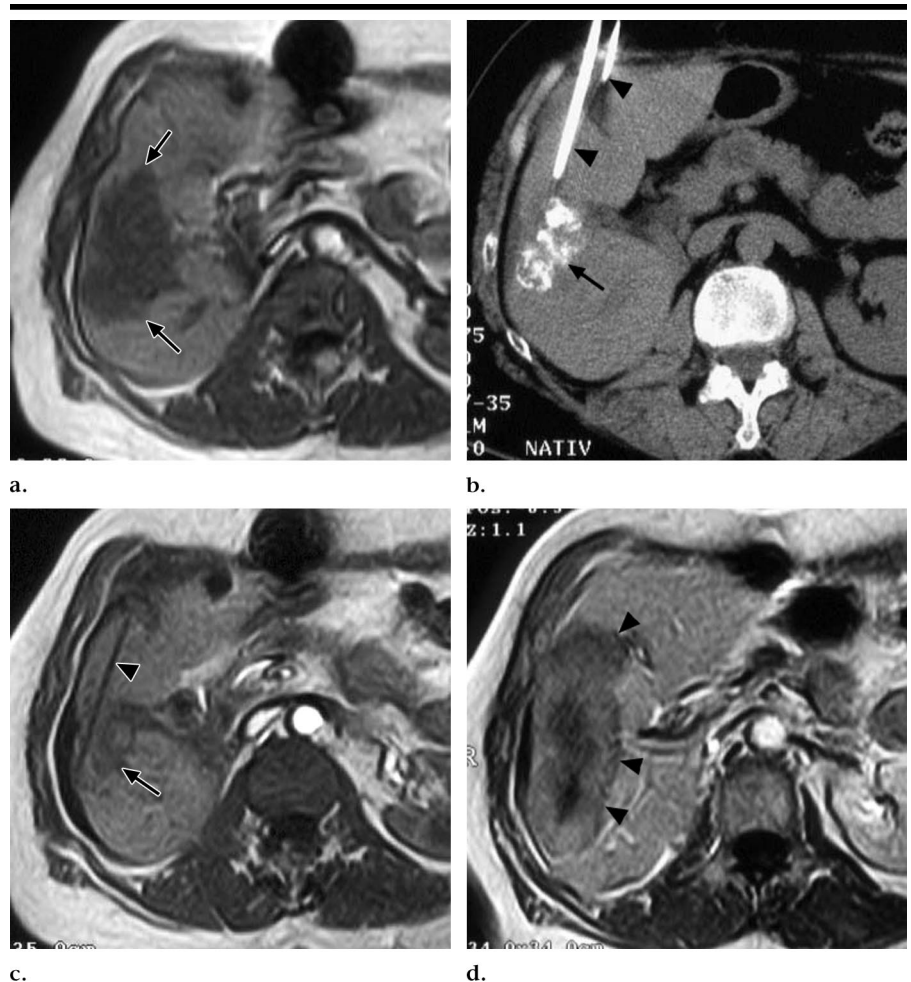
Images obtained in a 52-year-old man with bilobar colorectal liver metastases. (a) Unenhanced transverse gradient-echo T1-weighted MR image (140/12; flip angle, 80°) shows a 65×45 -mm target lesion (arrows) in segment VI with irregular borders before treatment. (b) Unenhanced transverse CT scan obtained after the third course of TACE during application of the laser catheters (arrowheads) shows residual tumor lesions, with attenuating area (arrow) caused by retention of iodized oil. (c) Unenhanced transverse T1-weighted gradient-echo MR image (140/12; flip angle, 80°) with residual lesion (arrow). Laser catheter (arrowhead) was placed laterally during application to achieve complete ablation. During the procedure, four catheters were applied. (d) Gadopentetate dimeglumine-enhanced transverse T1-weighted gradient-echo MR image (140/12; flip angle, 80°) obtained 24 hours after LITT shows demarcation of the volume of the induced necrosis (arrowheads). Note the sharp delineation of the border of the induced lesion.
